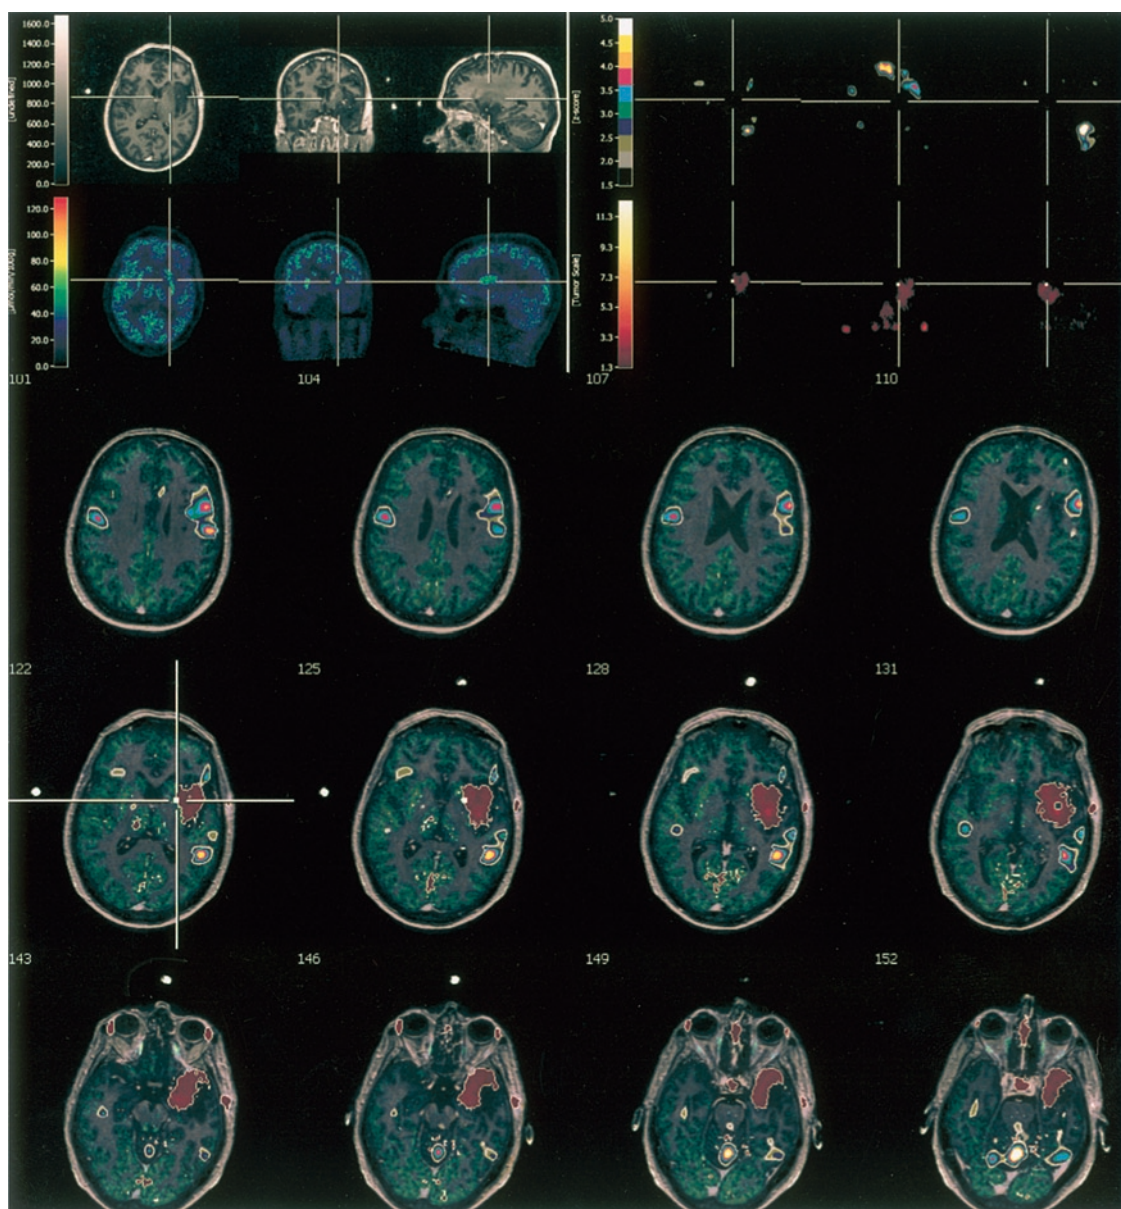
Multi-modal imaging of a low-grade glioma for surgical planning. A =  $T_1$  MRI; B =  $H_2^{15}$  O-PET activation study; C = FDG-PET; D = MET-PET with threshold set to display only high methionine uptake regions (including tumor); E = coregistered images of A–D (S. Vollmar, Max-Planck-Institute for Neurological Research, Cologne)
